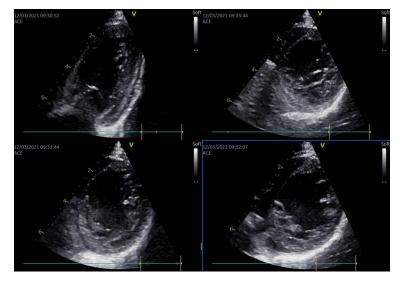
Apical and parasternal short axis views of the left ventricle.
